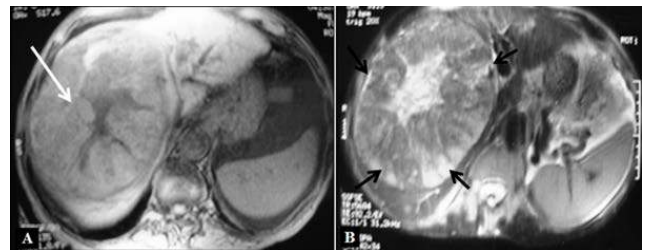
T1-weighted without contrast (A) and T2-weighted (B) axial hepatic MRI: heterogeneous aspect of hepatic mass (white arrow) with extensive arterial vascularization (black arrows)
